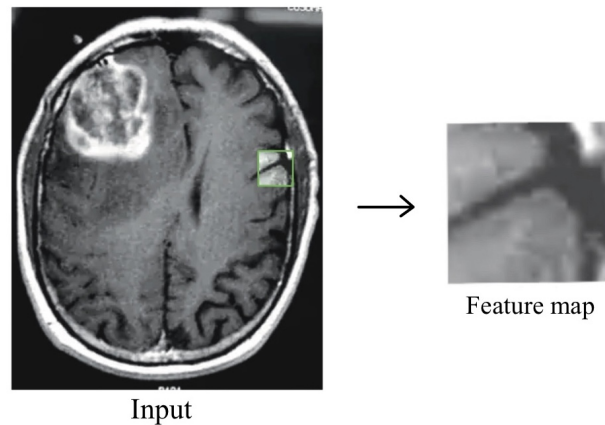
The convolutional layer finding low level features in a MRI scan of a brain with GBM
